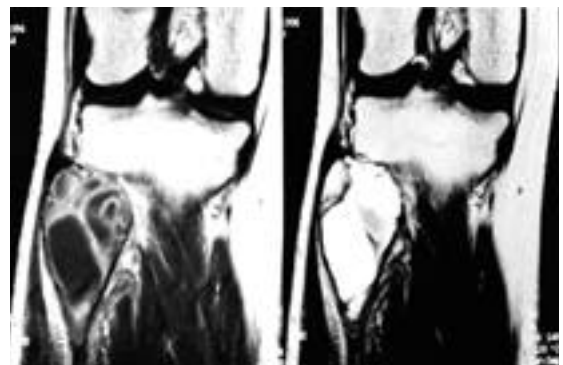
Preoperative coronal T1-weighted spin echo MR image of 25 year-old female showing low signal intensity in proximal epiphysis and meta-diaphysis of right proximal fibula and high signal intensity in T2-weighted image finally confirmed giant cell tumor.
